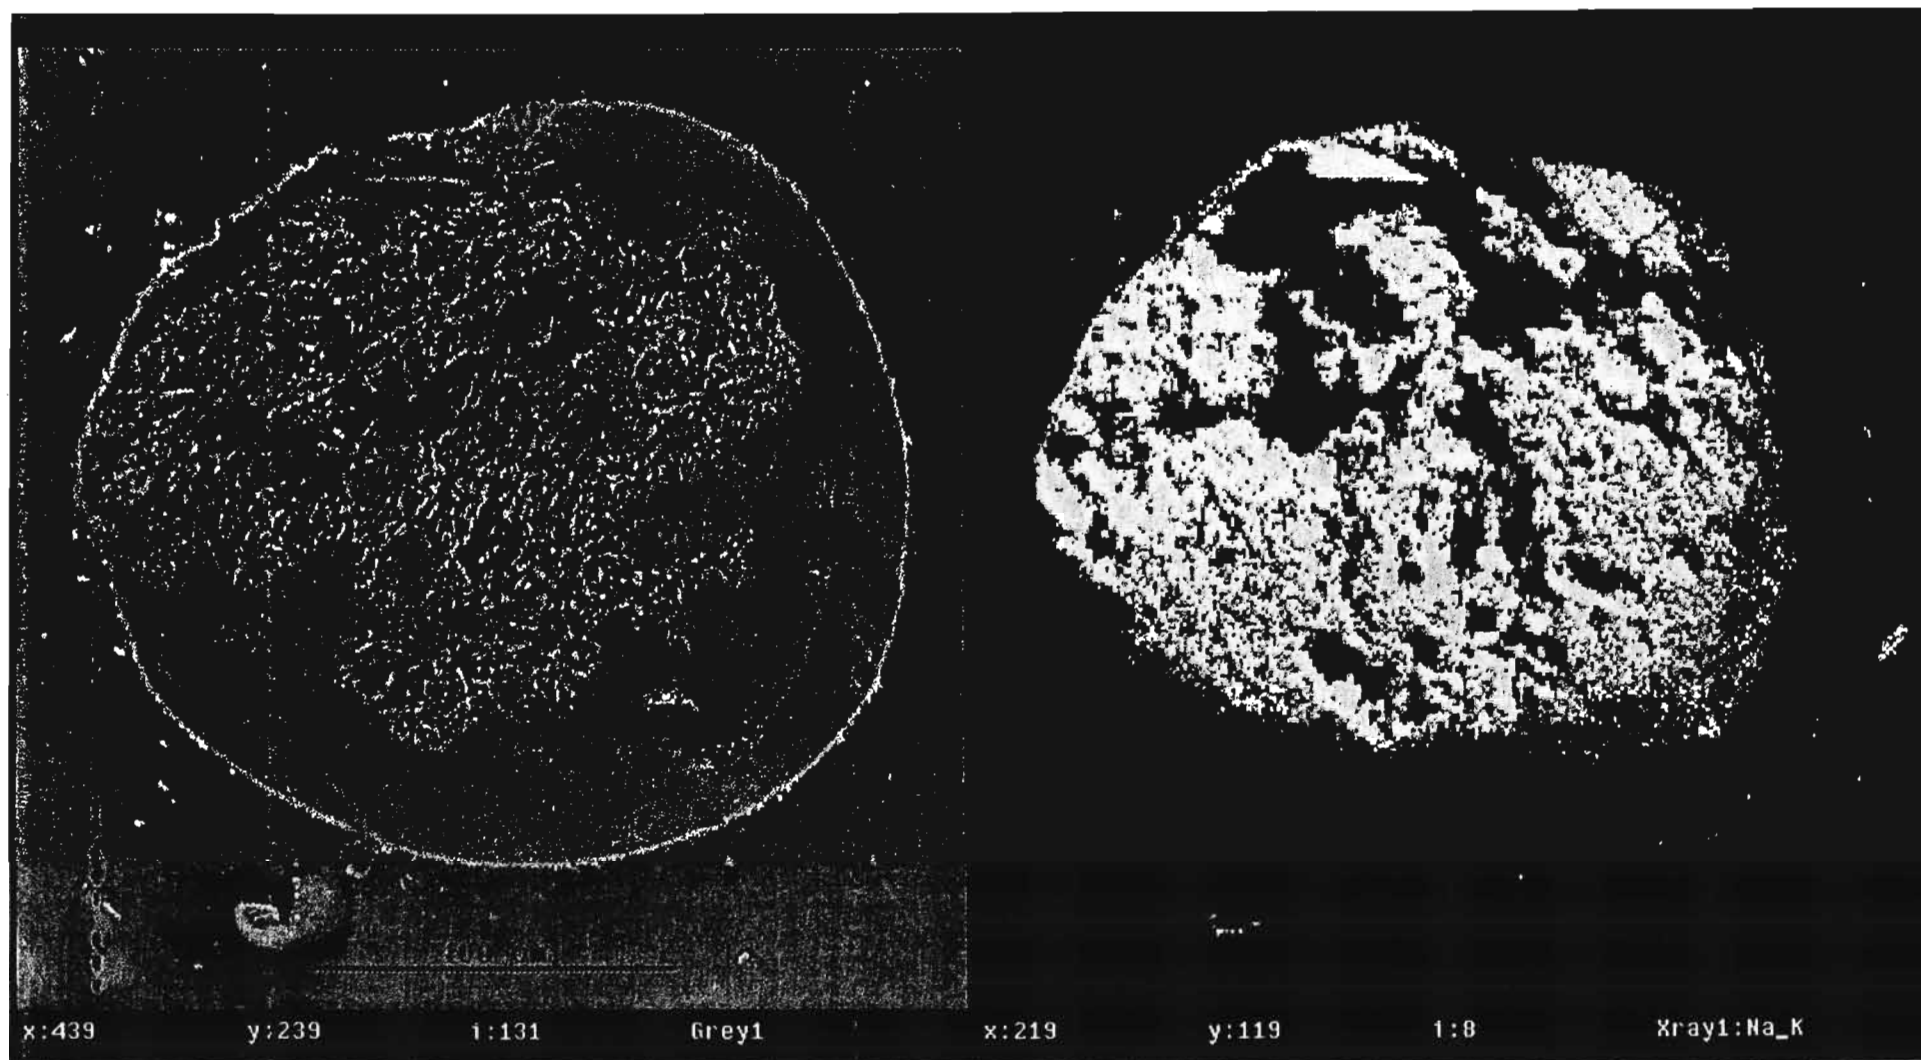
X-ray Map of a Cross-section of a Naproxen Sodium-Ethylcellulose Microcapsule (Batch NE3)
